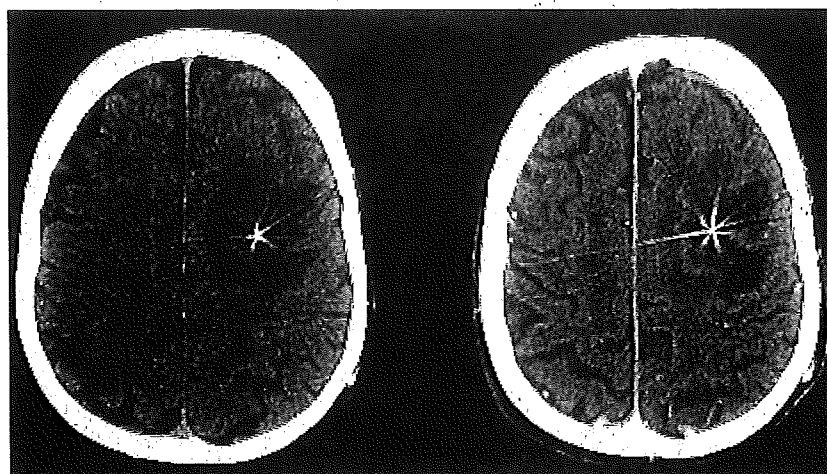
Computed tomography (CT) scan images of a brain abscess following DBS lead implantation. A CT scan image without contrast (left) revealed a low density area which indicated an edematous lesion surrounding the DBS lead. The lesion was enhanced with contrast media (right).
